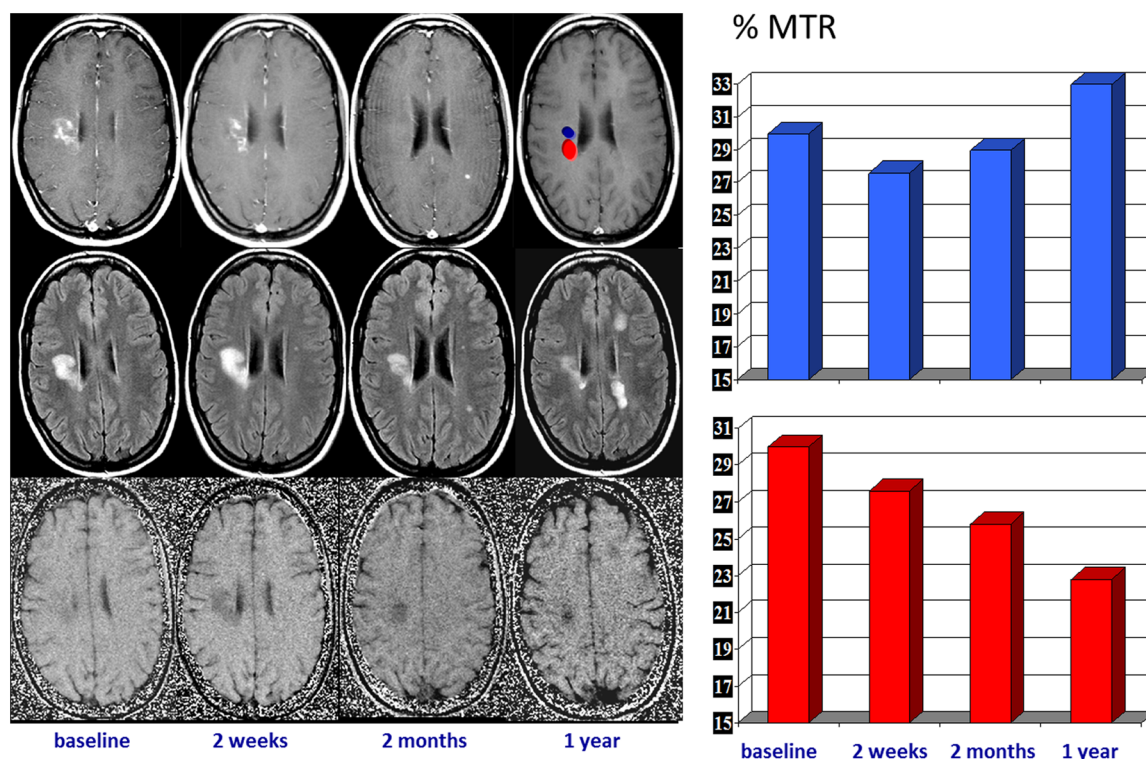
Serial magnetic resonance imaging changes occurring in an acute multiple sclerosis plaque located in the right centrum ovale. Contrast-enhanced T1-weighted images (upper row), T2-FLAIR images (middle row), and magnetization transfer (MTR) maps (lower row) obtained at baseline and at 7 days, 1 month, and 1 year later. The acute enhanced plaque shows the typical waxing and waning characteristics on T2-weighted images. The initial T2 lesion shrinkage observed after cessation of contrast uptake can be interpreted as a consequence of resorption of inflammatory edema, but the subsequent extended size decrease likely reflects a repair process. The serial MTR maps show two different components within the lesion, one with partial MTR recovery, likely reflecting remyelination, and the other with a progressive MTR decrease, likely reflecting ongoing demyelination (on the right, a plot of the serial MTR values obtained at the two locations). FLAIR, fluid attenuation inversion recovery.
